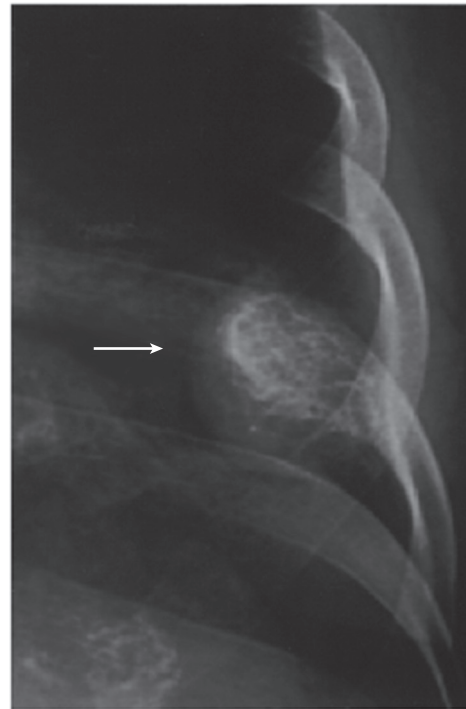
■ Rib radiograph showing a mass (arrow) that is located on the seventh rib and expands beyond the irregular cortex. Calcification inside the mass presents a so-called honeycomb appearance. (Reprinted with permission from Okumura T, et al: Hemangioma of the rib: a case report. *Jpn J Clin Oncol* 30:354–357, 2000.)
